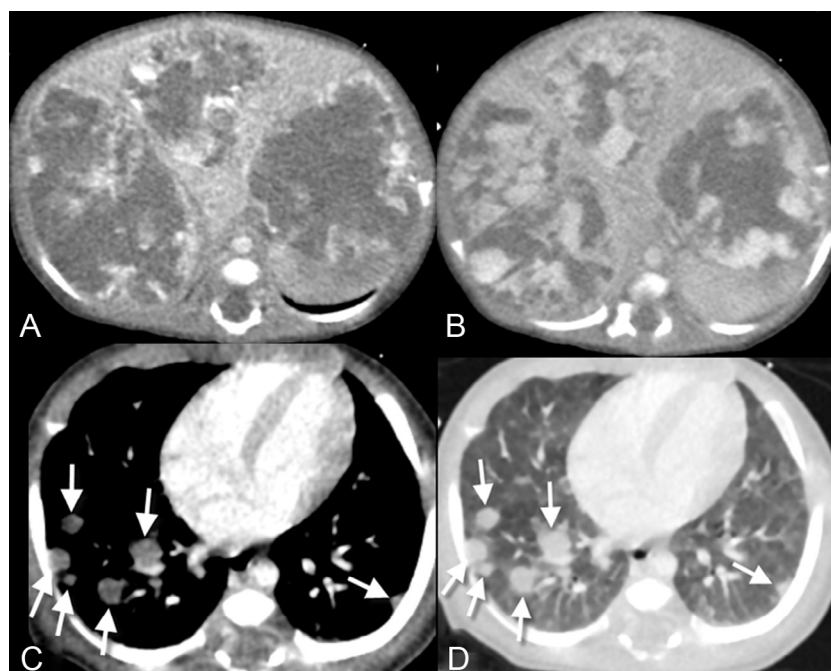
Axial contrast-enhanced CT of A, arterial and B, portal venous phases show 3 large hepatic masses with irregular heterogeneous early enhancement and some progressive heterogeneous enhancement (not centripetal) in portal venous phase. Axial chest CT of C, soft tissue and D, lung windows show multiple pulmonary nodules with similar attenuation (*arrows*).
